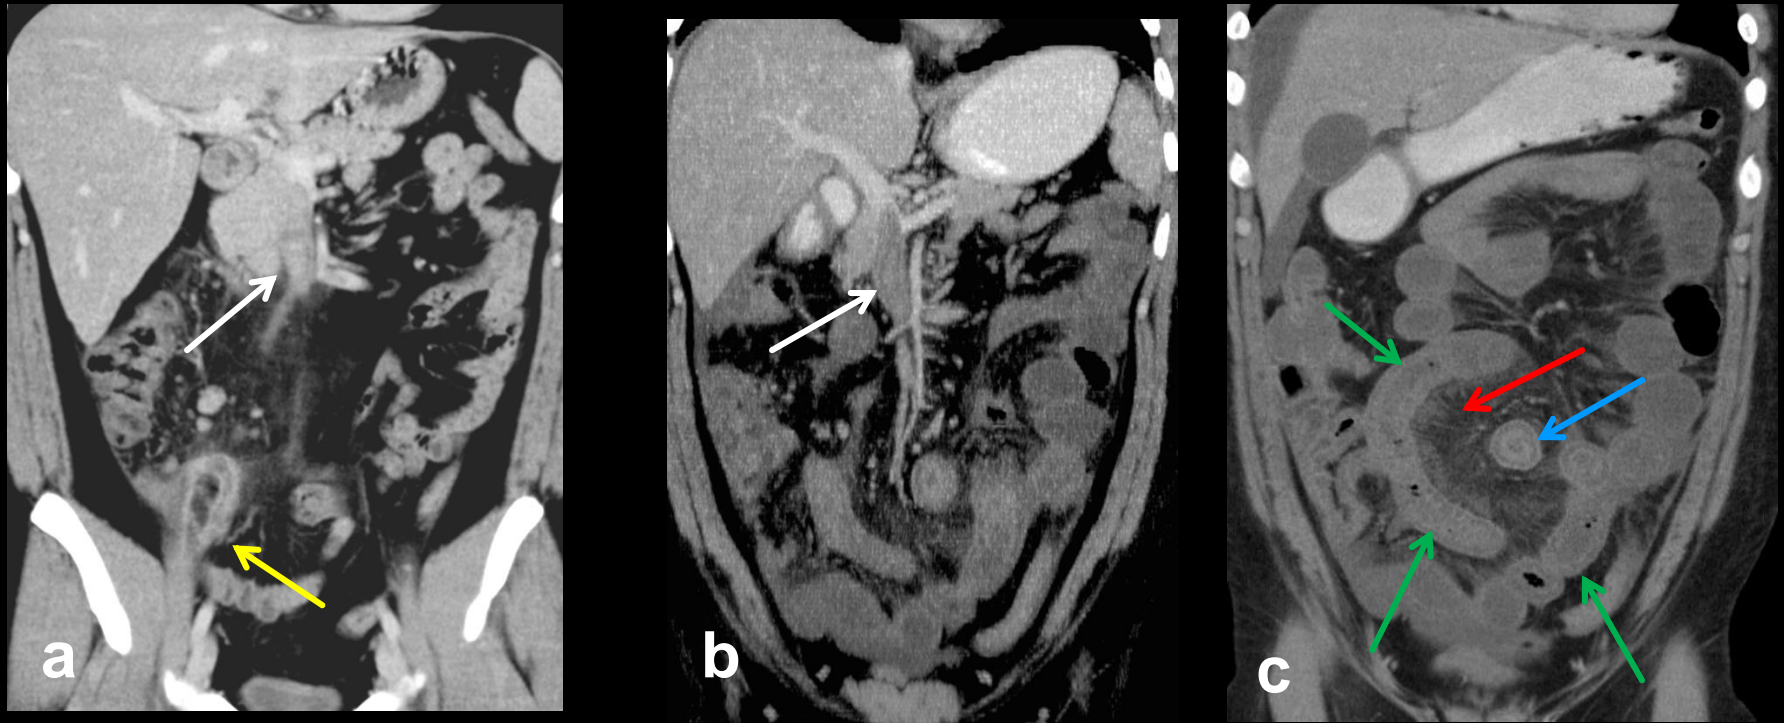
Coronal CT images of a 28-year-old man with appendicitis . In (a) thickened enhancing wall of the appendix (yellow arrow) and superior mesenteric vein thrombosis (white arrow). Four days after appendectomy and progressively worsening abdominal pain, another CT was performed (b,c). Note septic thrombus within the superior mesenteric vein (white arrow). In (c) signs of ischemia with mesenteric congestion (red arrow), thickened bowel walls (green arrows) and the “target sign”(blue arrow). Bowel ischemia and infarction are associated with a high morbidity and mortality.
